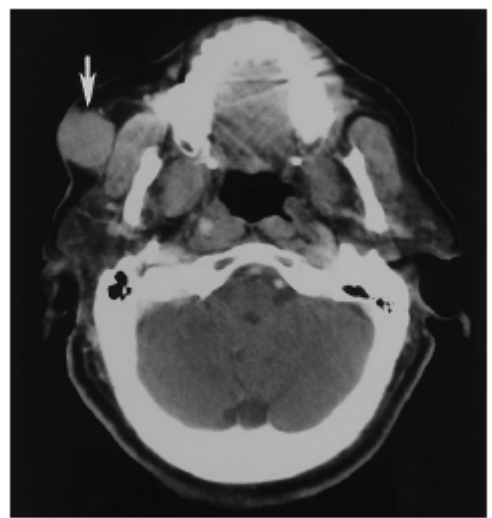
Contrast-enhanced head CT scan demonstrates a soft-tissue nodule (arrow) from MCC of the left cheek.
